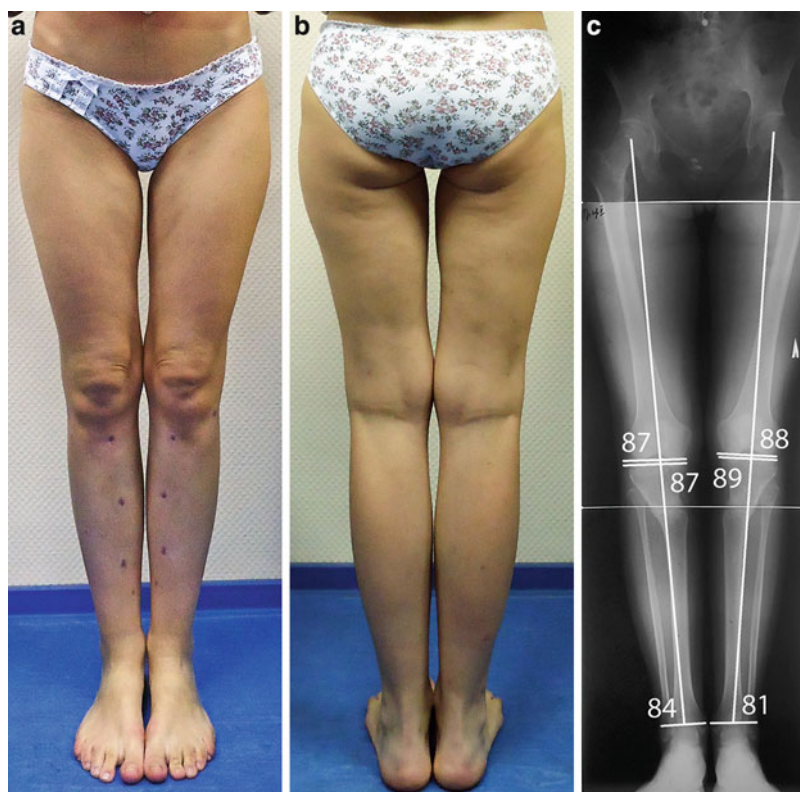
(a–c) Photos and radiographs 1 month after removal of the external fixation frames showing normal alignment. There is no mechanical axis deviation noted
